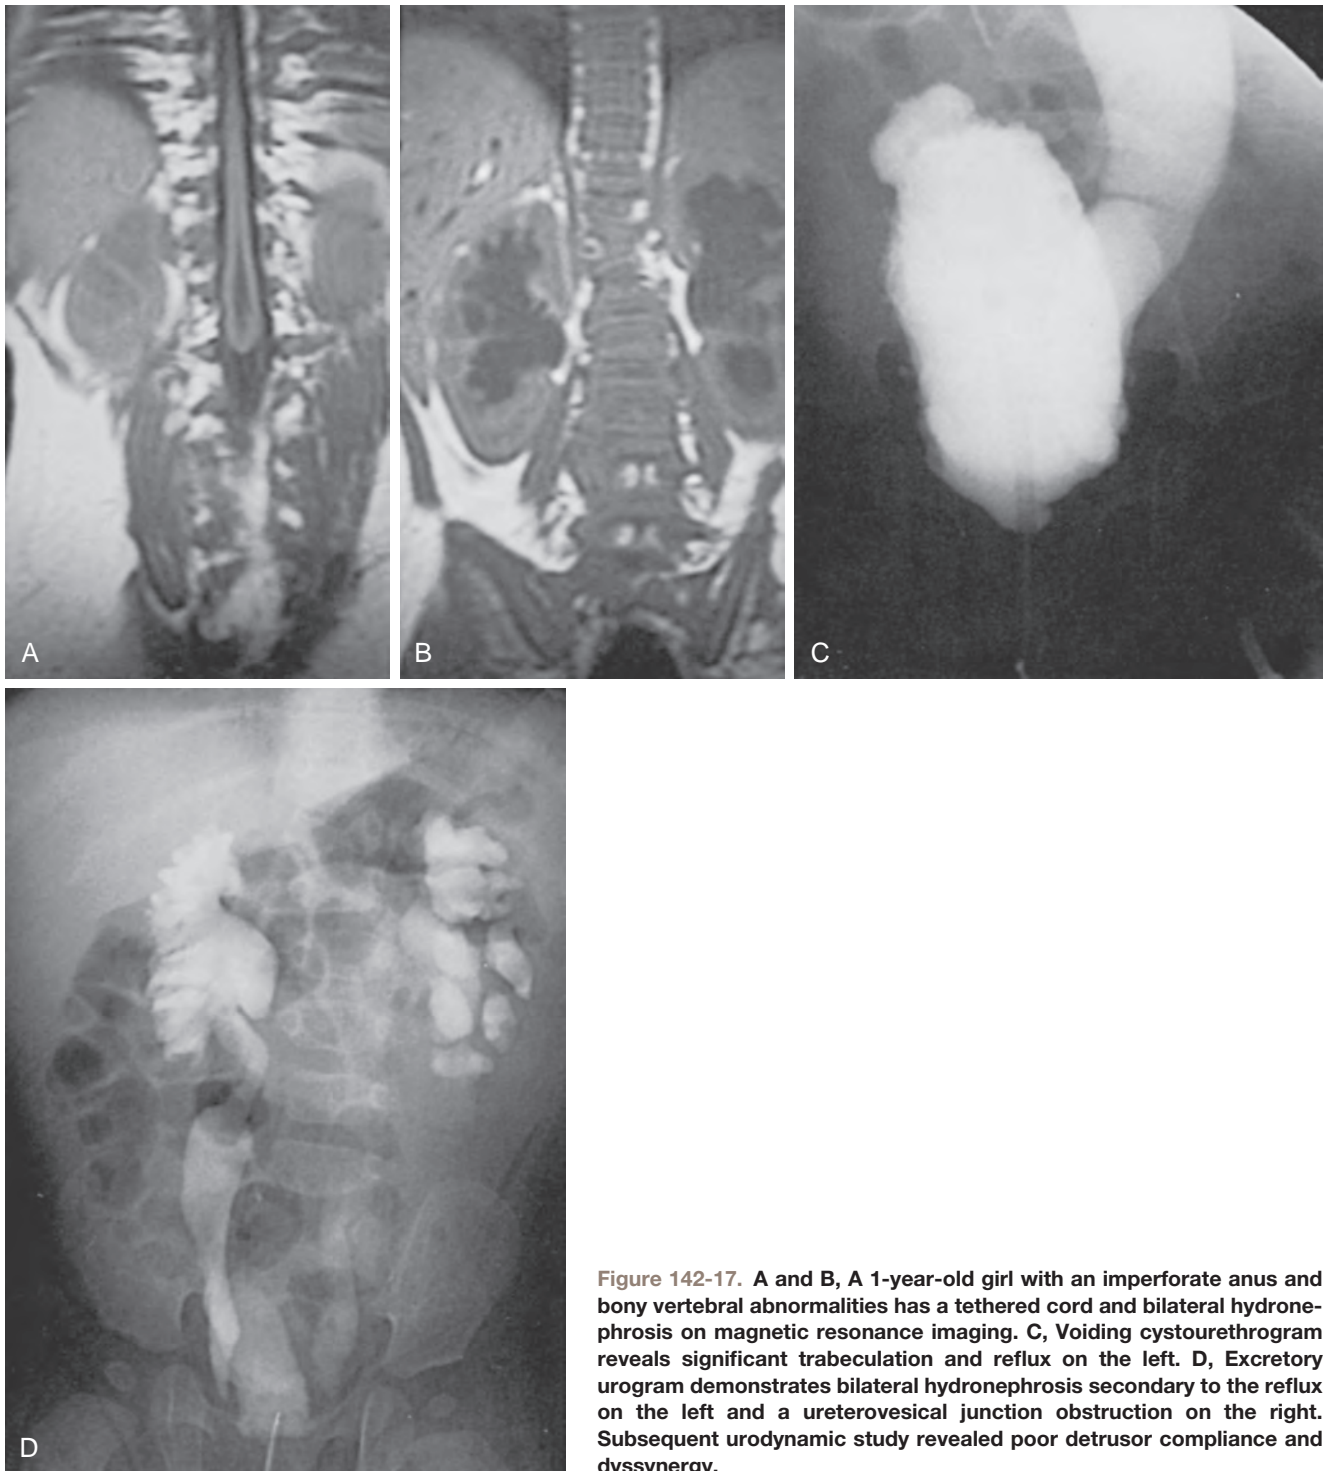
A and B, A 1-year-old girl with an imperforate anus and bony vertebral abnormalities has a tethered cord and bilateral hydronephrosis on magnetic resonance imaging. C, Voiding cystourethrogram reveals significant trabeculation and reflux on the left. D, Excretory urogram demonstrates bilateral hydronephrosis secondary to the reflux on the left and a ureterovesical junction obstruction on the right. Subsequent urodynamic study revealed poor detrusor compliance and dyssynergy.
